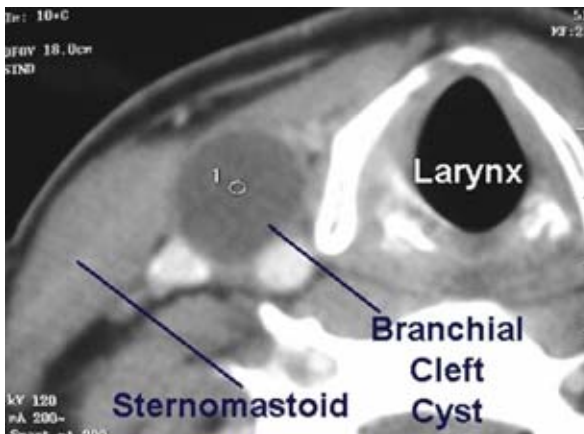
Case 1: Typical appearance of the lesion demonstrated by a CT scan.
